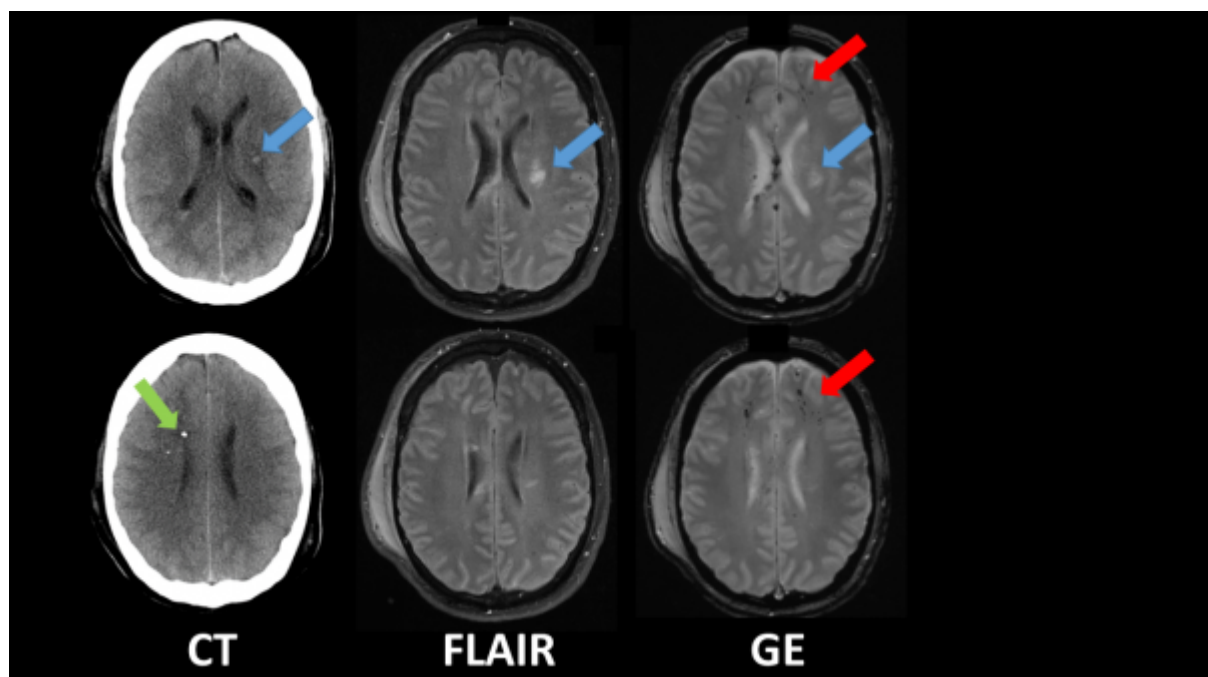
Detection of structural brain damage after TBI with CT and MRI. The green arrow points to a small hyperdensity which is the intraparenchymal probe, Blue arrow points to an area of oedema that
